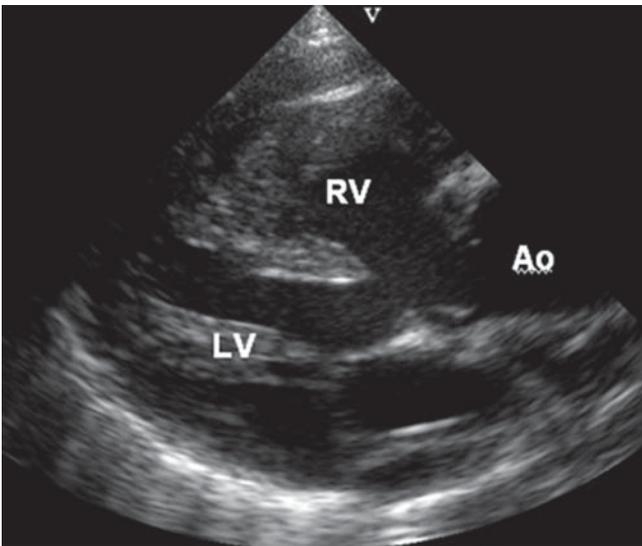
Tetralogy of Fallot. Parasternal long-axis view demonstrating the ventricular septal defect extending to the outlet part of the septum and the overriding aorta
